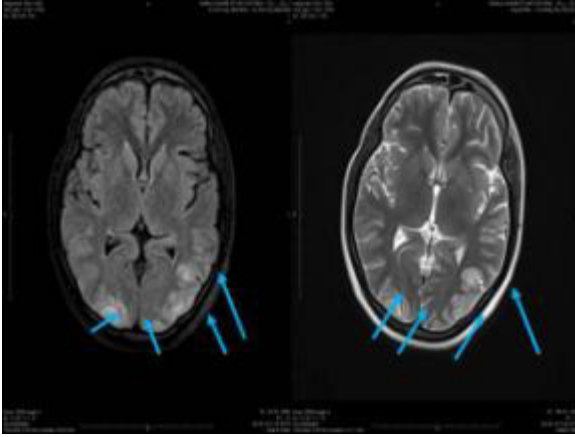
Axial FLAIR and T2 images show near symmetrical hyperintense areas of abnormal signal intensity in bilateral Parieto occipital Region
